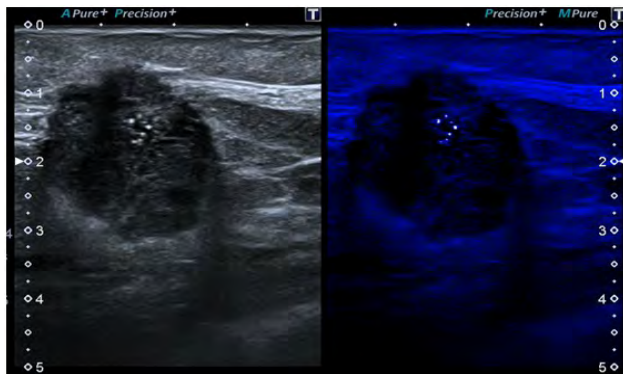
Pregnancy-associated breast cancer in a 34-year-old lactating woman, 7 months' post-partum, presented with a palpable mass in the left breast. Ultrasonography showed an irregular-shaped, hypoechoic mass at 12 o' clock position in left breast with micro lobulated margins and micro calcifications within the mass. Core needle biopsy revealed invasive ductal carcinoma. The patient received neoadjuvant chemotherapy followed by breast-conserving surgery.
